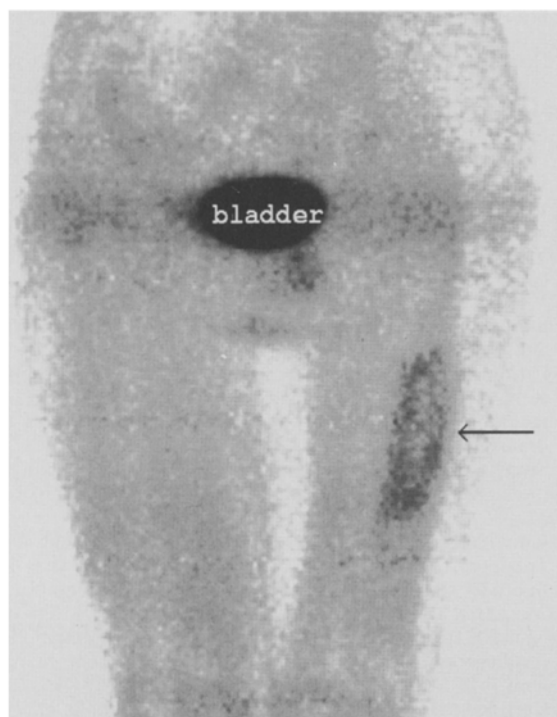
PET of patient 10, a 65-year-old woman. The anterior view shows increased uptake of FDG over a large area. Biopsy samples did not contain viable tumor tissue. However, 1 year after this PET scan, pathological proof of recurrence was obtained.
